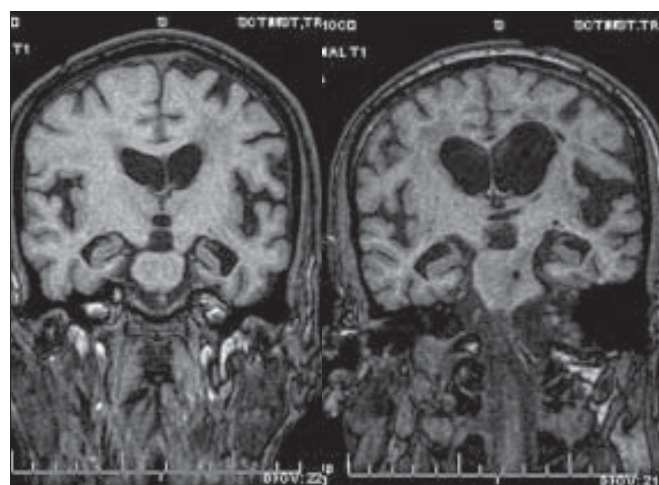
MRI Brain, coronal T1 sections, of the semantic dementia – Case 1 (left panel) and the progressive nonfluent aphasia patient – Case 2 (right panel) showing asymmetrical atrophy involving the left temporal lobe more than the right. The asymmetry is more marked in the patient with progressive nonfluent aphasia
